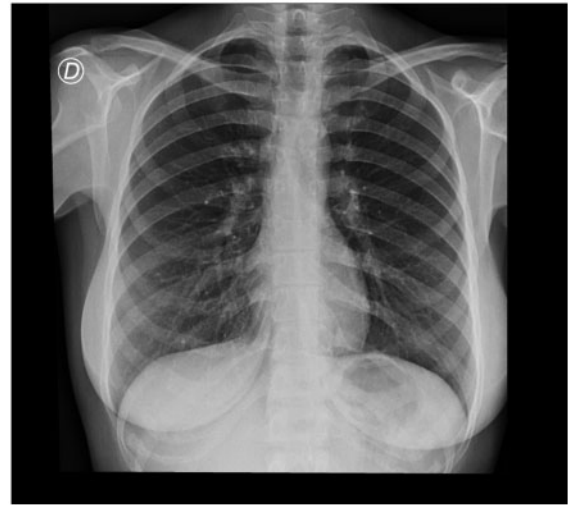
Posteroanterior chest X-ray in maximum inspiration, heart, and mediastinum size appears normal, costophrenic angles without presence of pleural effusion, gastric bubble in standard localization on the left side of the body, both lung fields appear clean without lung radiopacities or signs of intrathoracic mass.
